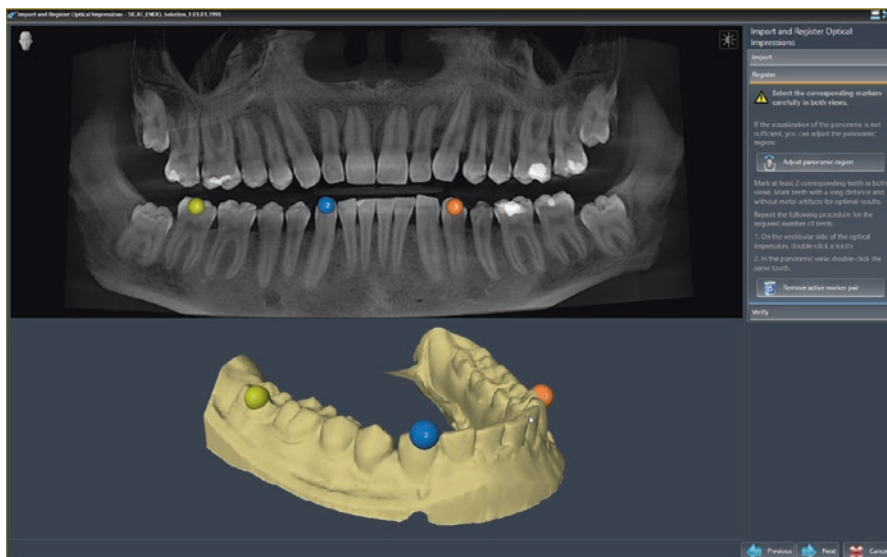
CBCT scan of the mandibular arch and surface STL data of an intraoral scan of the mandibular arch can be merged by identifying three landmarks (yellow, blue, and orange). Images from SICAT Endo® (SICAT, Bonn, Germany)
